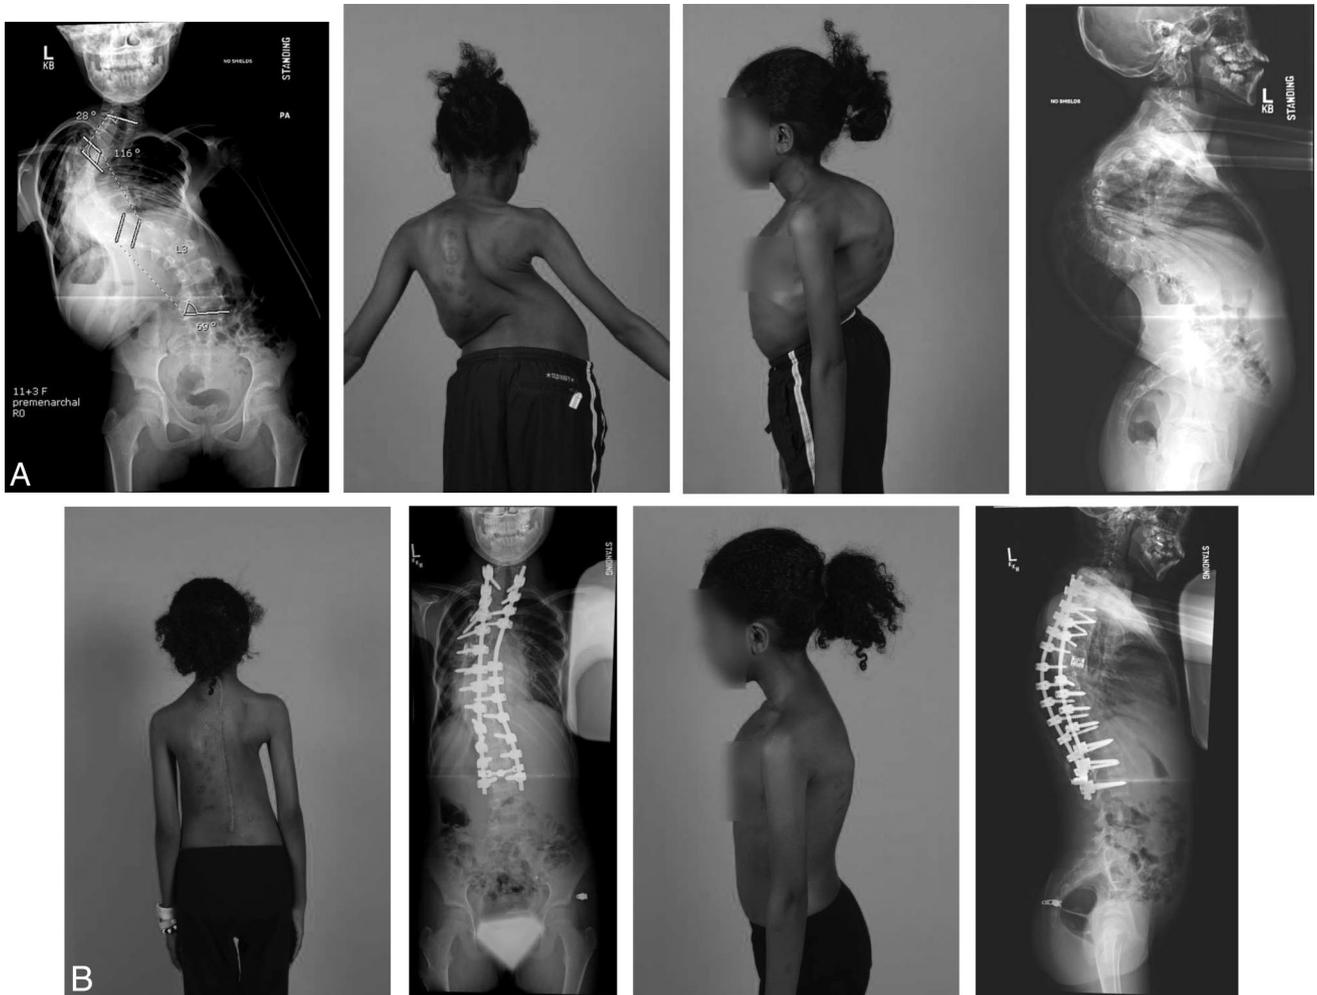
Posterior vertebral column resection. A, PA and lateral radiograph of a 14 year-old girl who has thoracogenic scoliosis. Her clinical pictures demonstrate her severe deformity. B, Postoperative radiographs following a posterior vertebral column resection over two levels and posterior instrumentation and fusion from T1–L3. The clinical appearance demonstrates marked improvement in her trunk height, coronal balance and overall appearance of her spine and chest.
